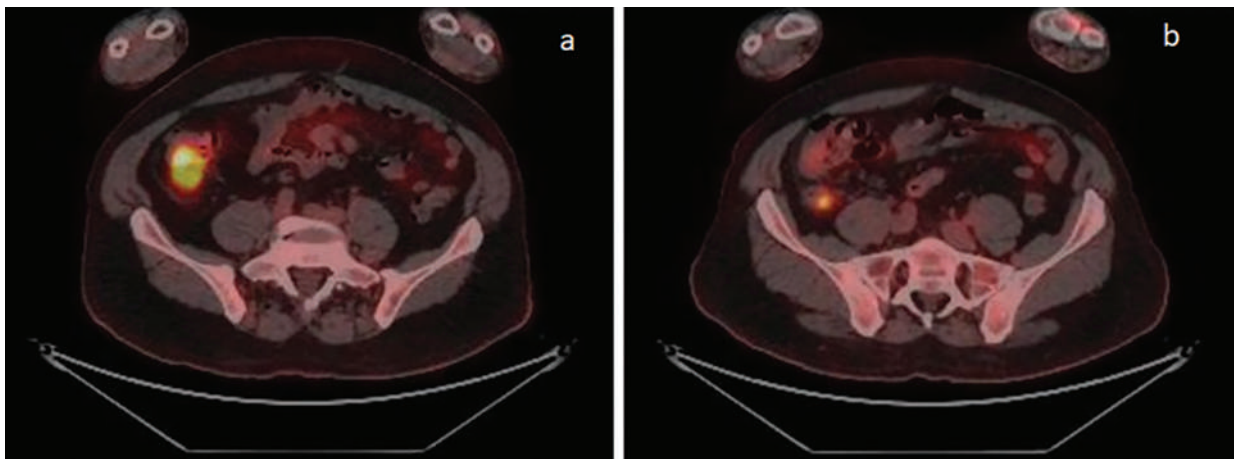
PET-CT. a) Involvement of the ascending colon. b) Involvement of the appendix.
